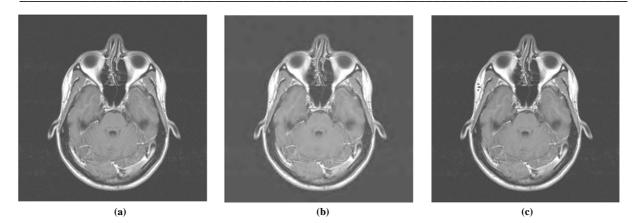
(a) Original MRI image (b) Reconstructed image using SPIHT (CR = 6.1, PSNR = 37.38 dB) (c) Reconstructed image using the proposed algorithm (CR = 6.7, PSNR = 36.97 dB)
